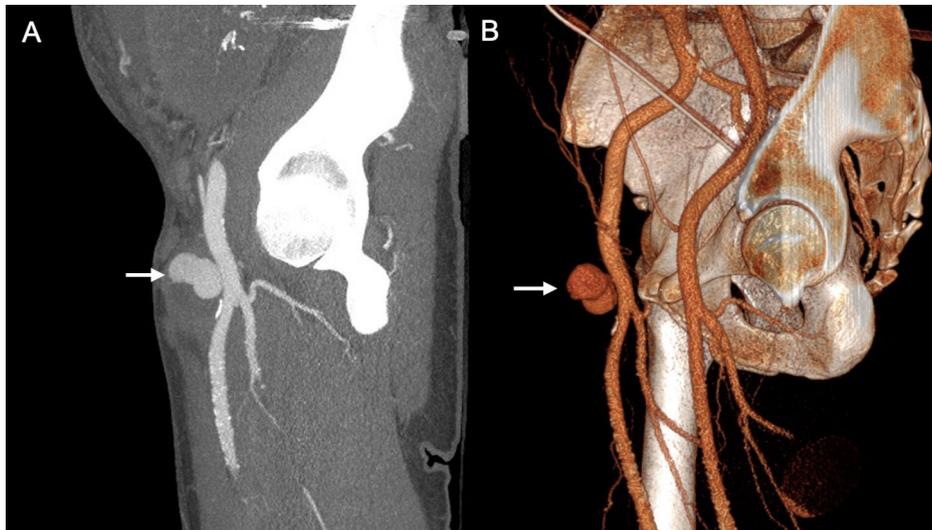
29-year-old man on peritoneal dialysis with a history of renal transplant who had embolization of the transplanted kidney one month ago, and since then developed a mass in the right inguinal region where the puncture was made. Sagittal maximum intensity projection (A) and 3D (B) CT angiography reconstructions of the right lower limb in arterial phase showing a bilobed pseudoaneurysm (arrow) arising from the right common femoral artery.
